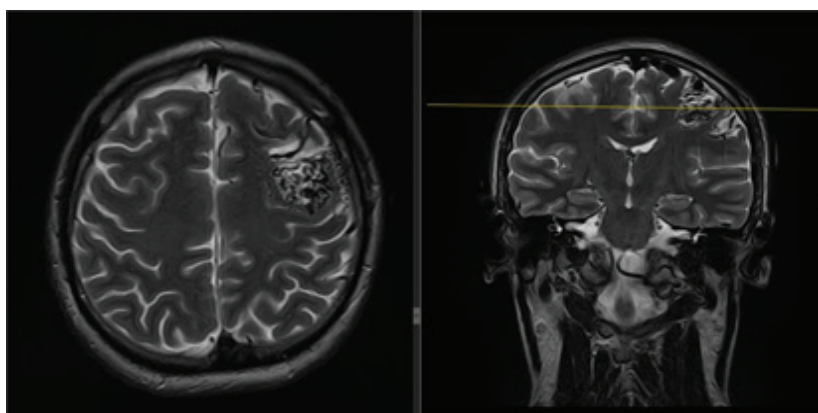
Magnetic resonance imaging of the brain of patient A. (29 years old): Condition after partial embolization of AVM.
